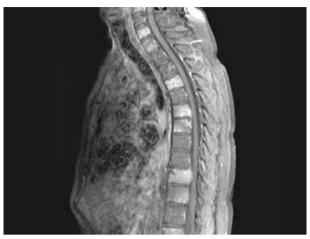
Neuro-axis magnetic resonance imaging with tumor infiltration was observed in cervical, thoracic, and lumbosacral regions.
